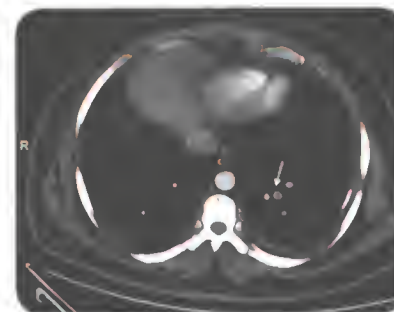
Computed tomography pulmonary arteriography showing filling defect (arrow) in the subsegmental branches of the left descending pulmonary artery suggesting thromboembolism
